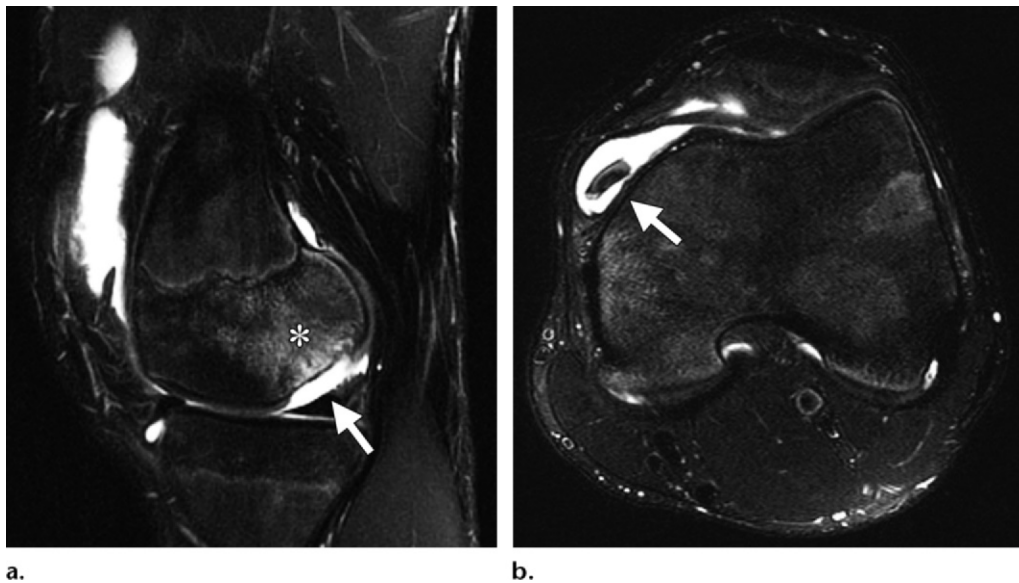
Acute osteochondral injury in a 16-year-old male adolescent that was sustained while playing basketball. (a) Sagittal fat-suppressed T2-weighted MR image of the knee shows an osteochondral defect in the posterior third of the femoral epiphyseal cartilage (arrow) with associated bone edema (*). (b) Axial fat-suppressed T2-weighted MR image at the level of the distal femur shows a loose osteochondral body (arrow) and joint fluid.
